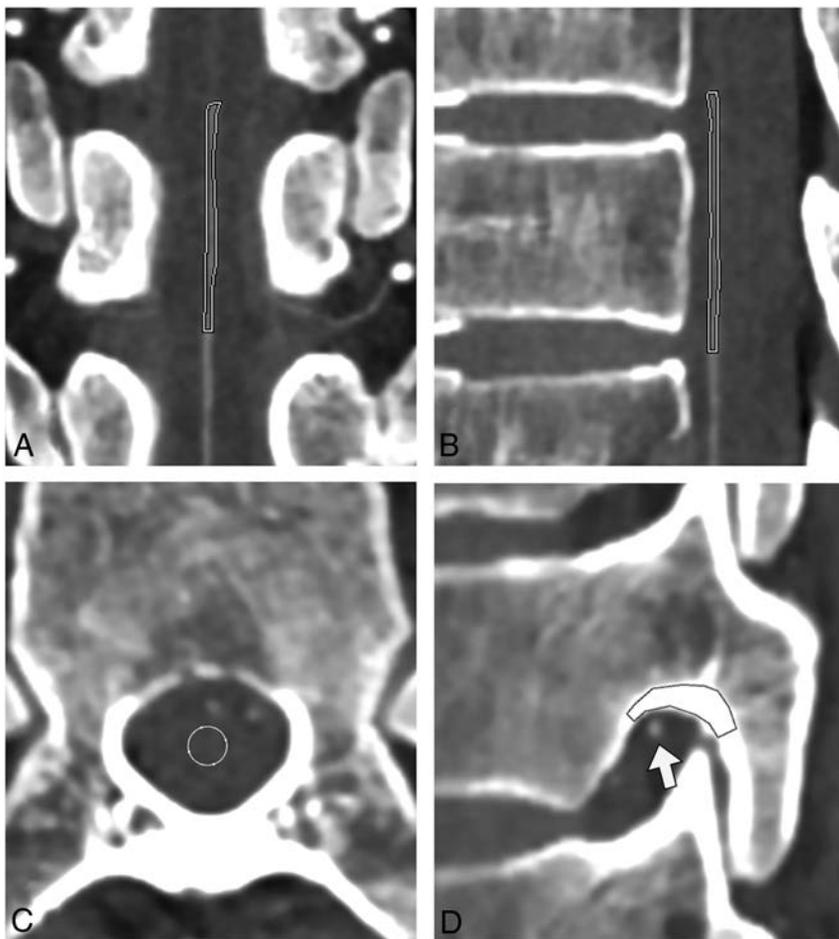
The ROIs placed for measuring CT numbers are shown in a coronal image of the ASA (A), a sagittal image of the ASA (B), an axial image of the spinal cord (C), and a sagittal image of the vertebral bone cortex around the vertebral foramen at the AKA (white arrow) running level (D).
